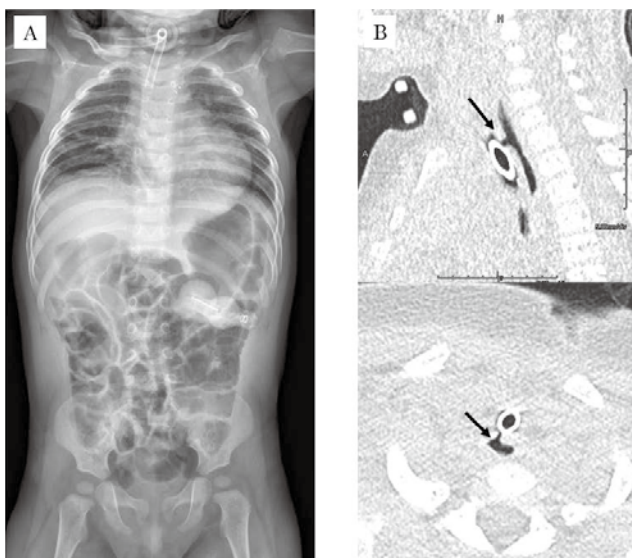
A) The X-ray, B) The plain chest CT findings at 14 months of age (Arrows indicate tracheoesophageal fistula.)
